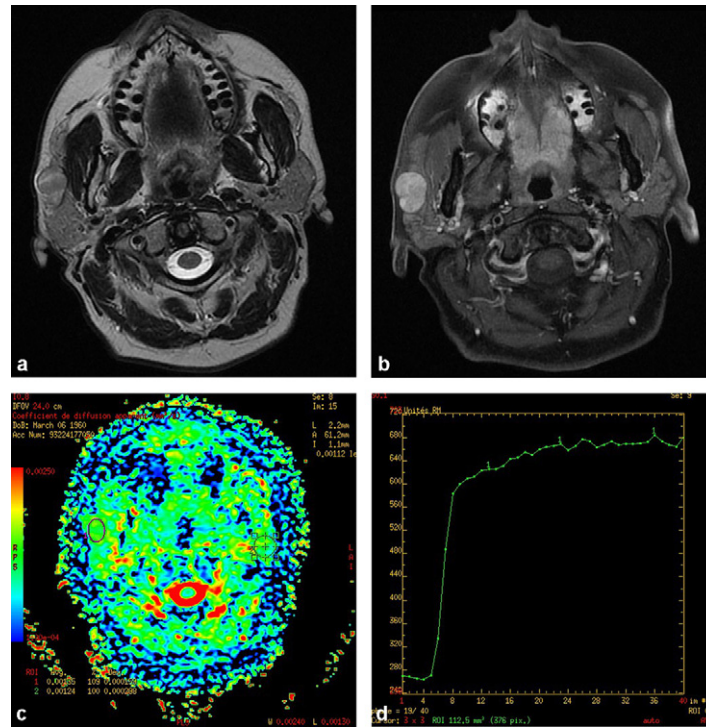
Cellular pleomorphic adenoma. 2 cm tissular formation of the superficial right parotid lobe: a: T2-weighted axial slice: lesion in isosignal on T2-weighted image; b: T1-weighted gadolinium-enhanced fat-sat axial slice: intense uptake; c: apparent diffusion coefficient map: ACDr = 1.09; d: perfusion curve showing intense uptake with ascending plateau.
